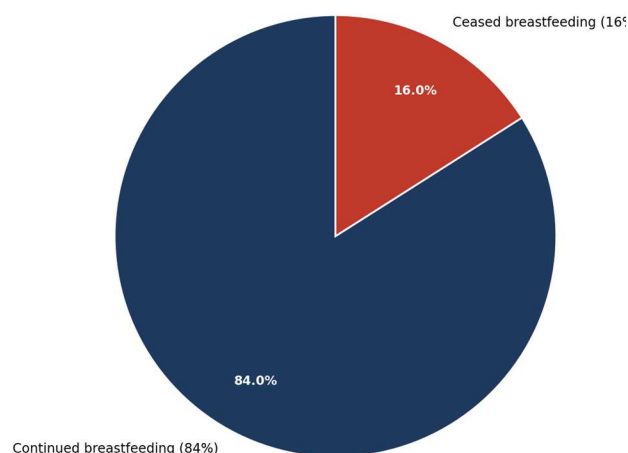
Breastfeeding continuation among patients managed with ultrasound-guided needle aspiration — 84% were able to continue breastfeeding, compared with 0% in the I&D group.
